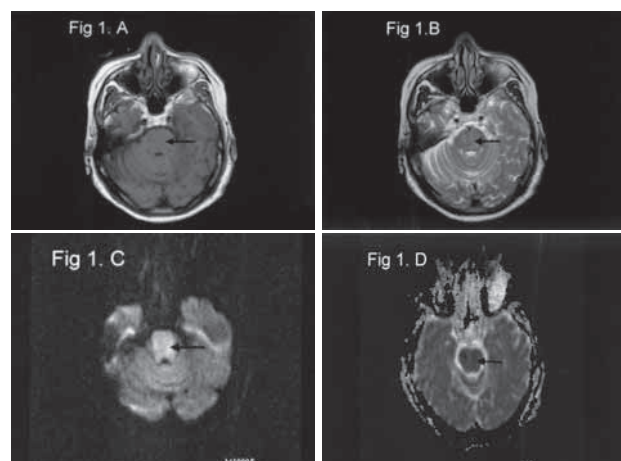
(A): T1-weighted magnetic resonance imaging with an arrow pointing to the iso to hypo intensity area in the most of pons. (B): T2-weighted magnetic resonance imaging with an arrow pointing to the iso to hyper intensity area in the most of pons. (C): Diffusion-weighted (DWI) magnetic resonance imaging with an arrow pointing to increase signal in the most parts of pons. (D): Apparent diffusion coefficient (ADC) magnetic resonance imaging with an arrow pointing to decrease signal in the most parts of pons.
